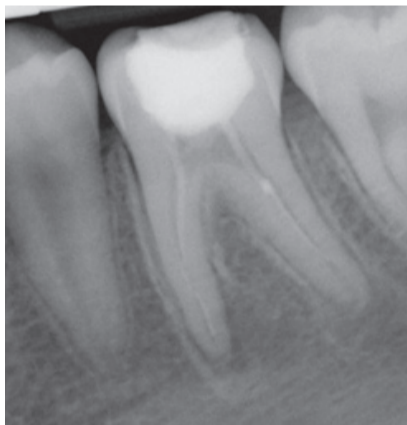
The radiograph showed radiolucency associated with the mesial and distal roots, and inadequate root canal treatment
